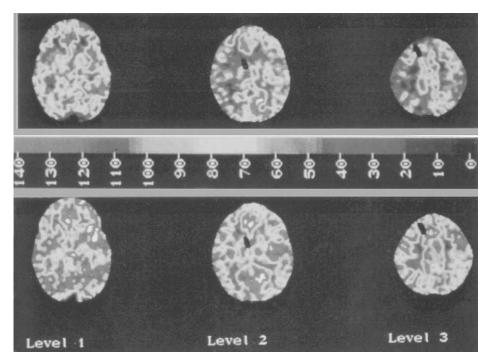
CBF as measured by stable xenon CT in a shaken baby with refractory intracranial hypertension despite maximal medical management including barbiturate coma. (*Top row*) Normal or increased CBF at a cerebral perfusion pressure (CPP) of approximately 40 mm Hg. (*Bottom row*) Increasing blood pressure by norepinephrine administration (despite CPP within the autoregulation range) resulted in a concomitant increase in CBF and intracranial pressure, demonstrating a loss of autoregulation. (See also Color Plate 2.)
